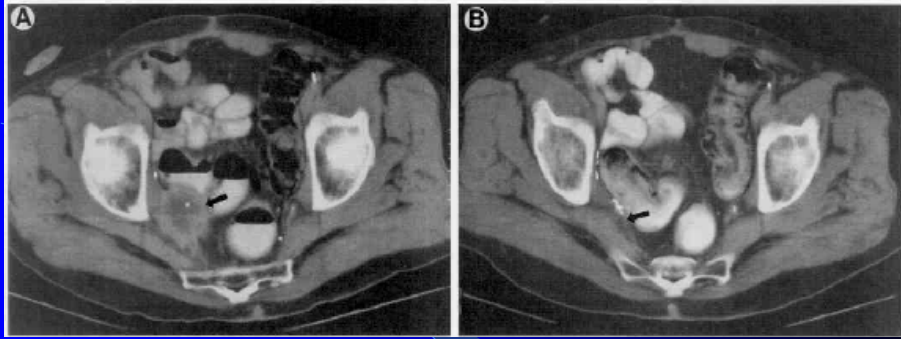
Routine followup CT of 46-year-old asymptomatic patient 4 months after radical cystoprostatectomy. A, 4.5 x 3.0 cm. right pararectal mass (arrow) is visible. B, 4 months after treatment with 3 courses of vinblastine, ifosfamide and gallium, there was stable resolution of disease (arrow).
